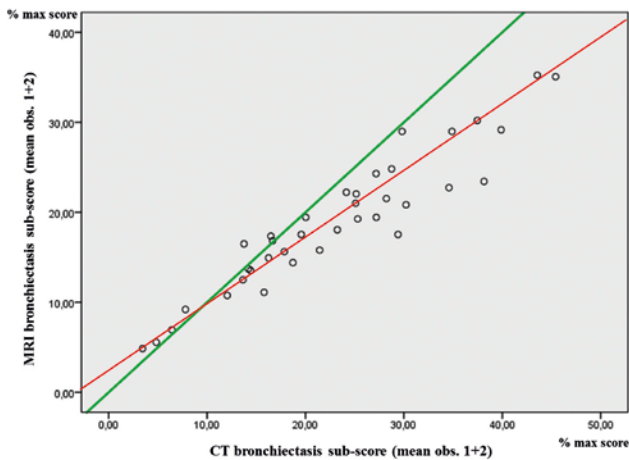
Identity plot MRI-bronchiectasis versus CT-bronchiectasis sub-scores (mean score observer 1+ observer 2). Green line identity line $Y=1 * X+0$. Note that MRI tends to overestimate mild CF cases and underestimate severe CF cases (red line).
